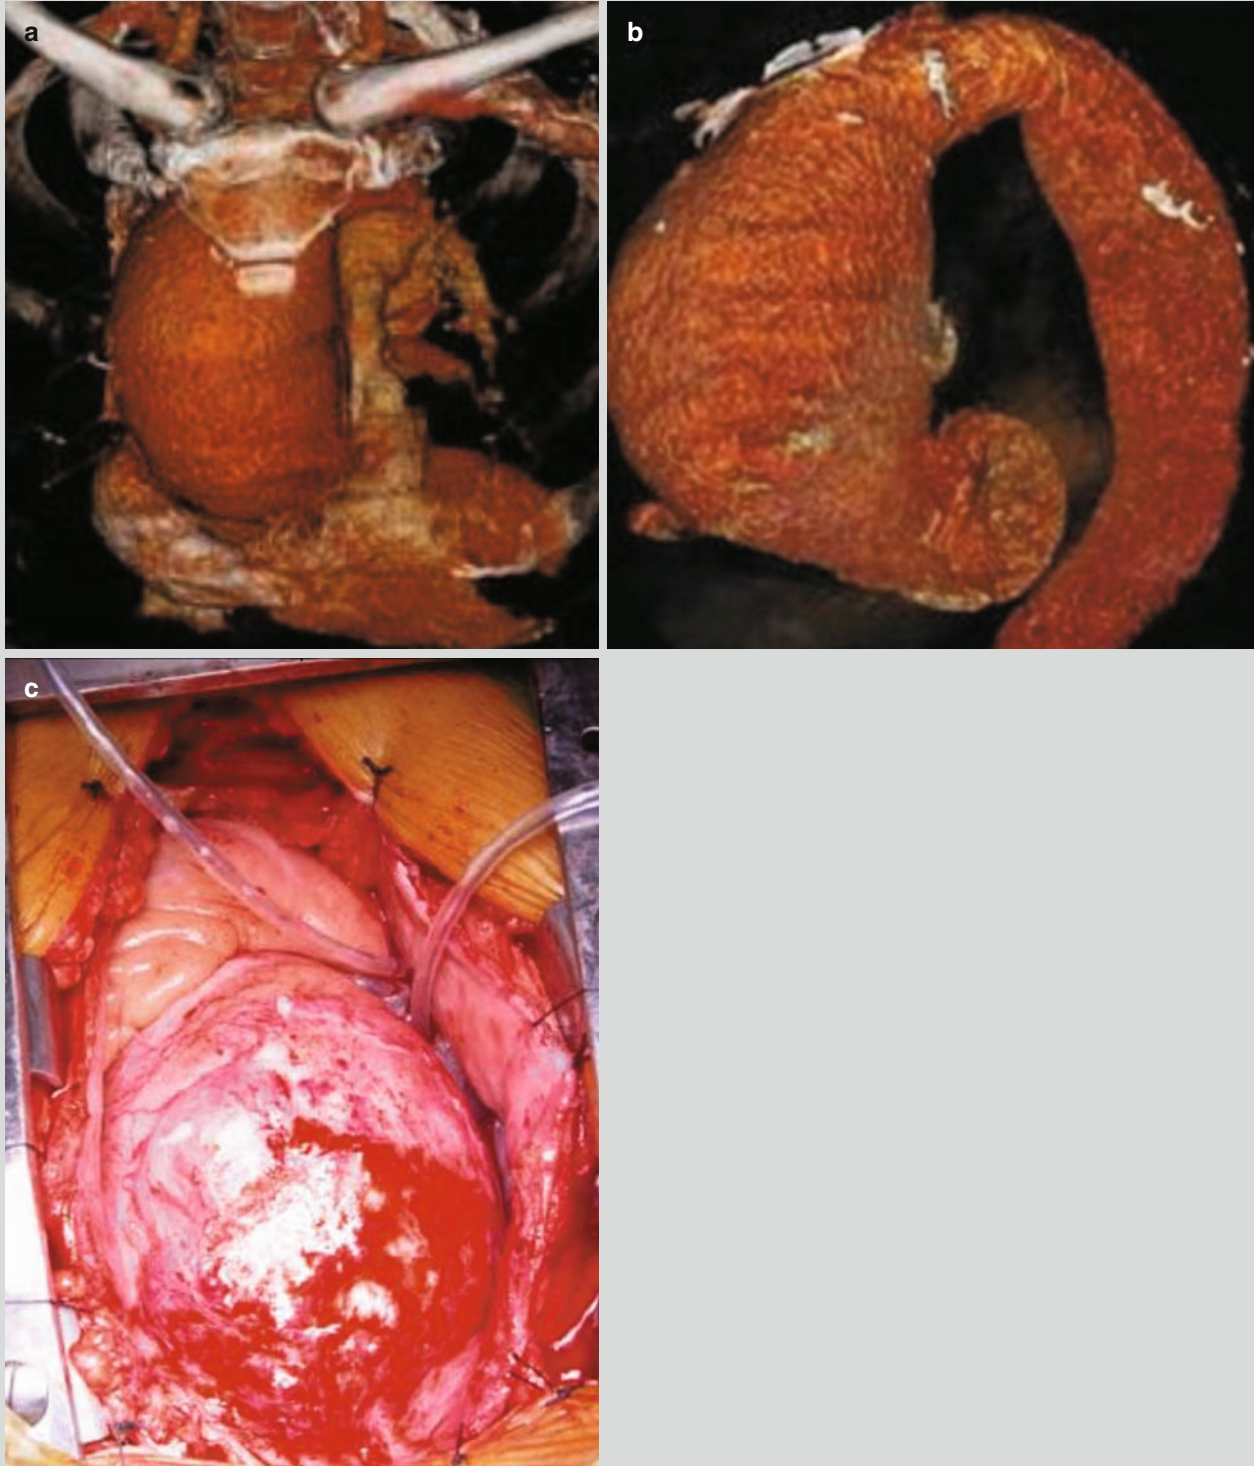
Syphilitic aortic aneurysm. (a, b) VR of CT scanning demonstrates aneurysm at the ascending aorta. (c) Observations during surgery to remove the aneurysm (Reprint with permission from Paulo N, et al. *Interact Cardiovasc Thoracsurg*, 2012, 14 (2): 193)
